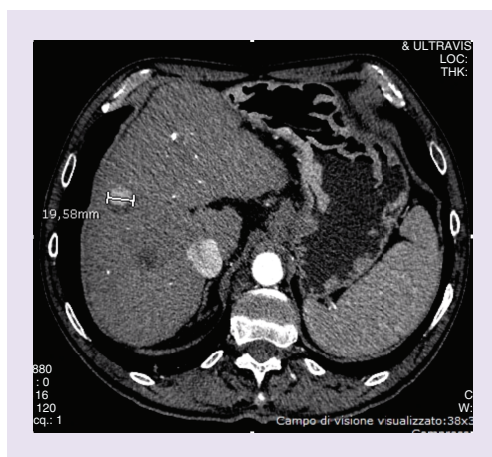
Computed tomography showing a viable tissue adjacent to a nonenhancing embolized lesion. Example of measurement according to modified Response Evaluation Criteria in Solid Tumor.
